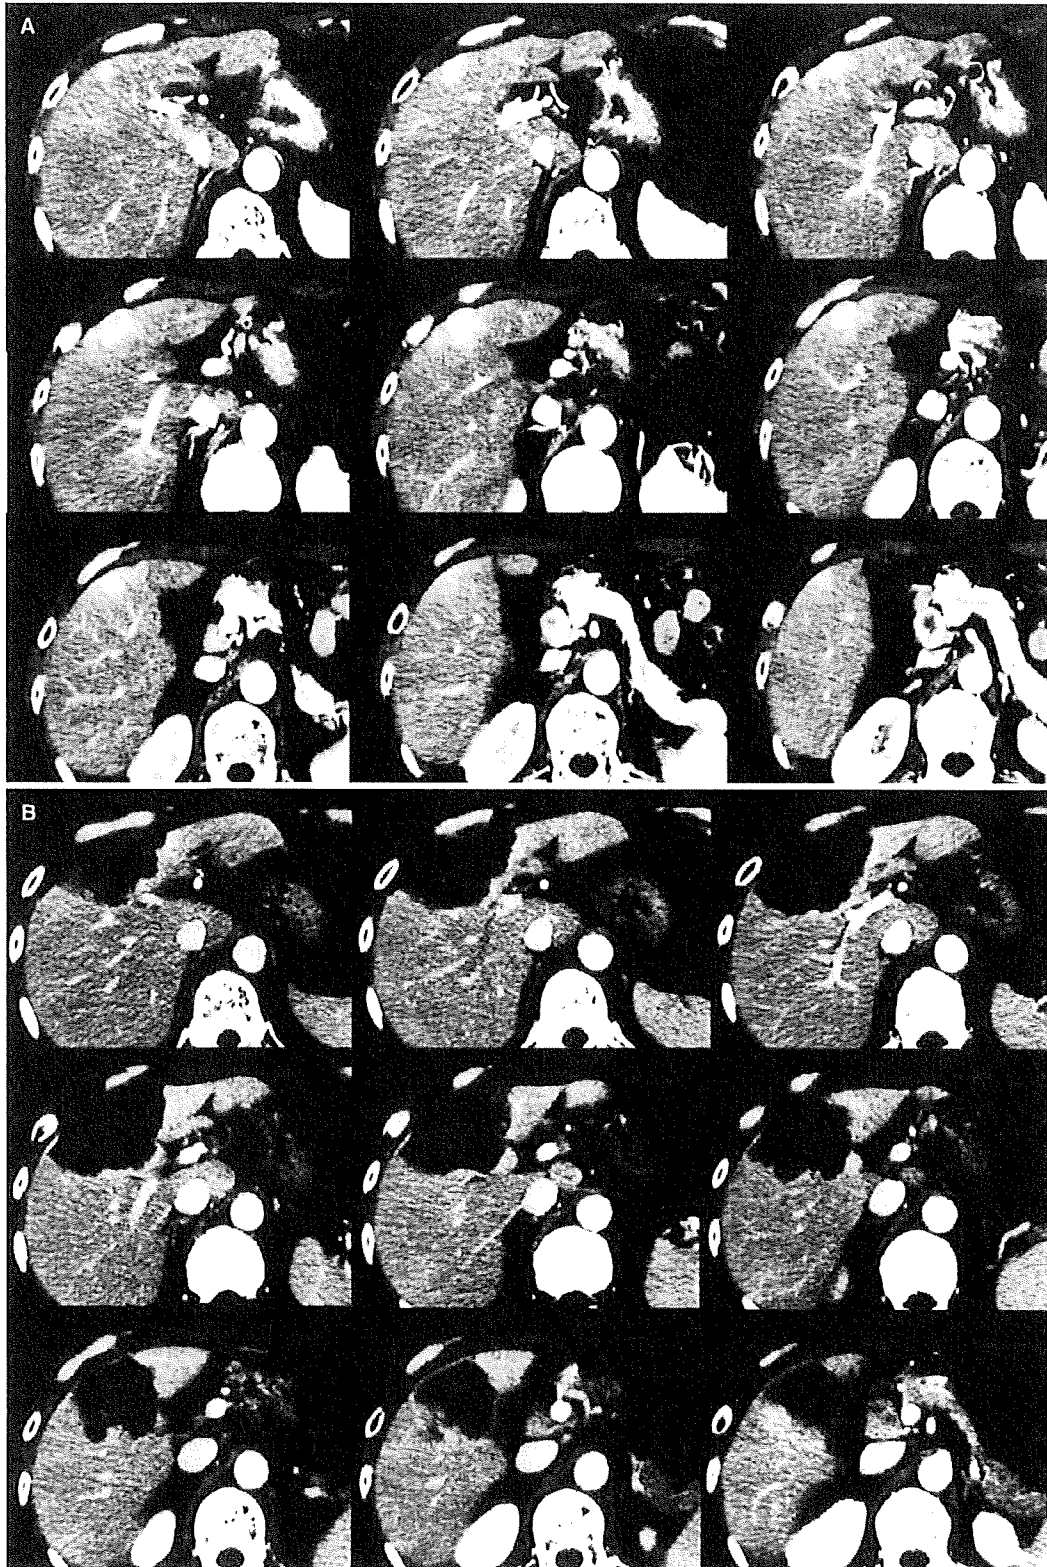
A A 62-year-old man had confluent multinodular type hepatocellular carcinoma of 4 cm on the surface in S4. B Computed tomography scan taken after two sessions of radiofrequency ablation demonstrated that not only the lesion but also some amount of surrounding tissue had become necrotic. We judged that a local cure was certainly achieved even for this confluent multinodular type lesion
